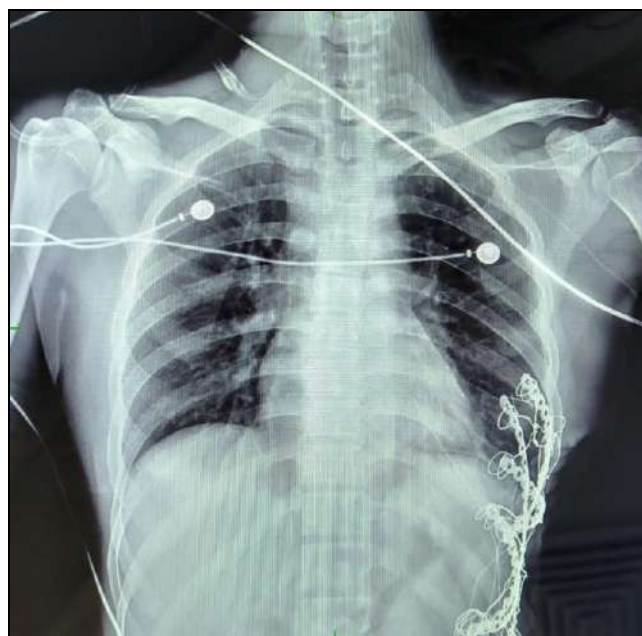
Postoperative X-ray examination
